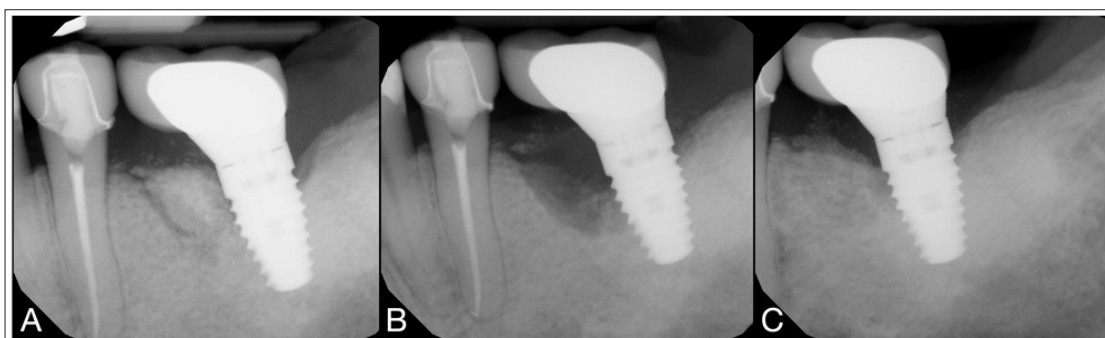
A) Pre-operative radiograph. B) Intra-operative radiograph after removal of necrotic bone. C) 2-year post-operative radiograph
